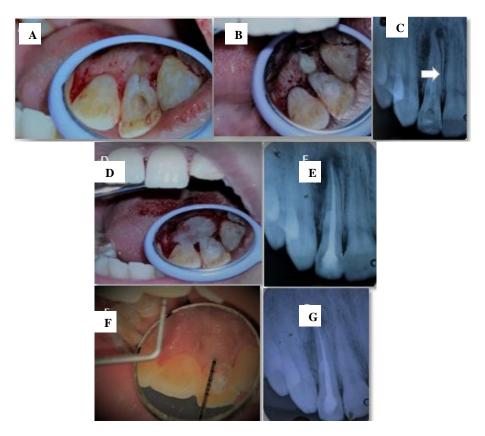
(A, B) The debridement of the groove followed by sealing with MTA (C) The radiograph after placement of MTA, note the sealing of the groove area (D, E) After placing GTR membrane and obturation (F, G) Over 12-month recall period probing revealed no pockets beyond 3mm and radiograph showing excellent periapical healing.
